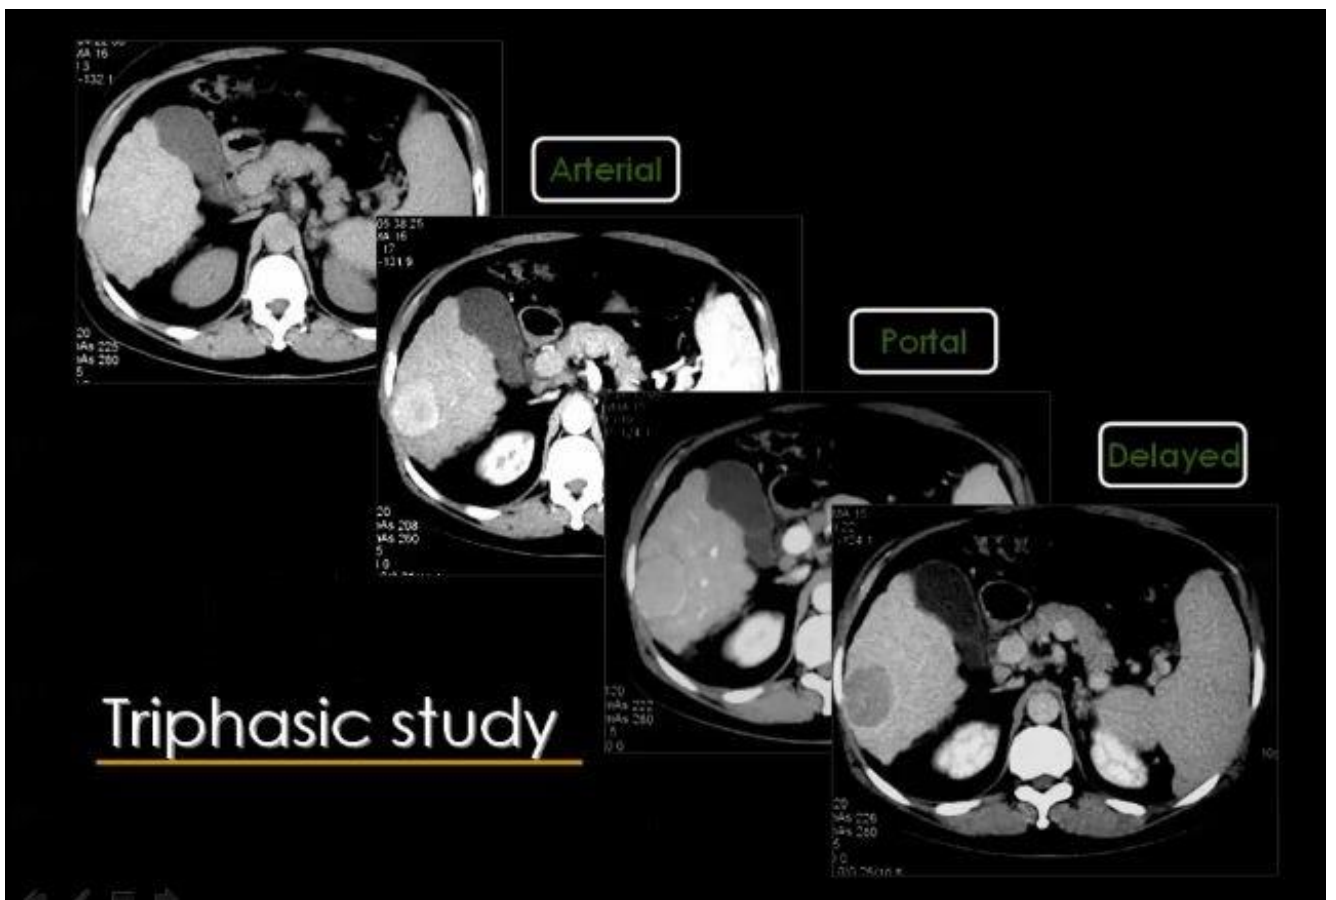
Triphasic of contrast liver CT
